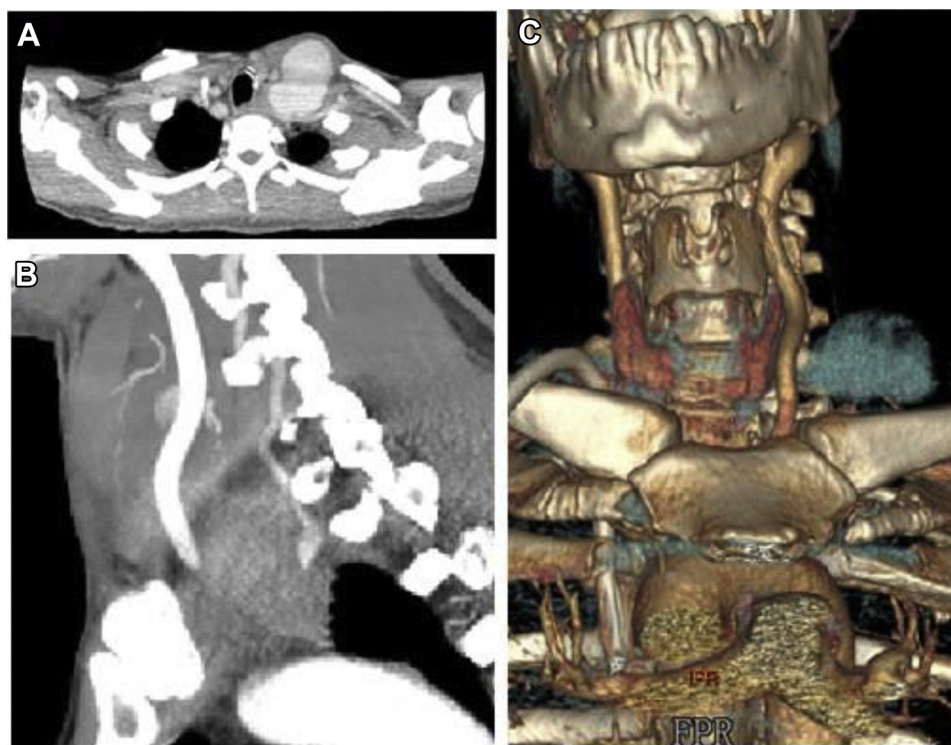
A, Computed tomography (CT) angiography of the neck and chest showing a left subclavian pseudoaneurysm measuring 6.6 cm. B, Sagittal image of the CT scan demonstrating the origin of the left vertebral artery, which was proximal to the subclavian pseudoaneurysm. C, Three-dimensional reconstruction of the CT scan demonstrating a left subclavian pseudoaneurysm superior and deep to the left clavicle.
